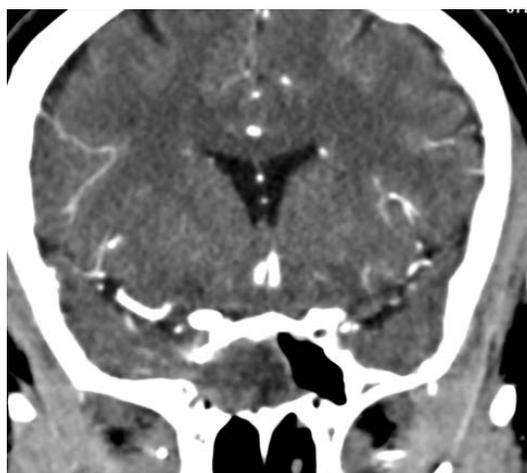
Coronal contrast-enhanced CT scan shows herniation of right temporal lobe tissue into the sphenoid sinus through a bony defect in the lateral wall of the sphenoid sinus.
